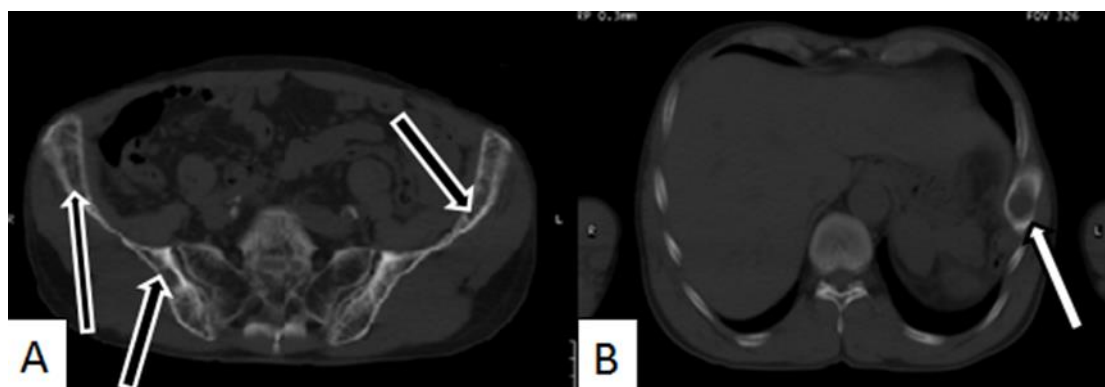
CT axial views; (A) multiple lytic lesions in pelvic bones (black arrows). In (B) ; expansile bony lesions along the left 9th rib (white arrow)
